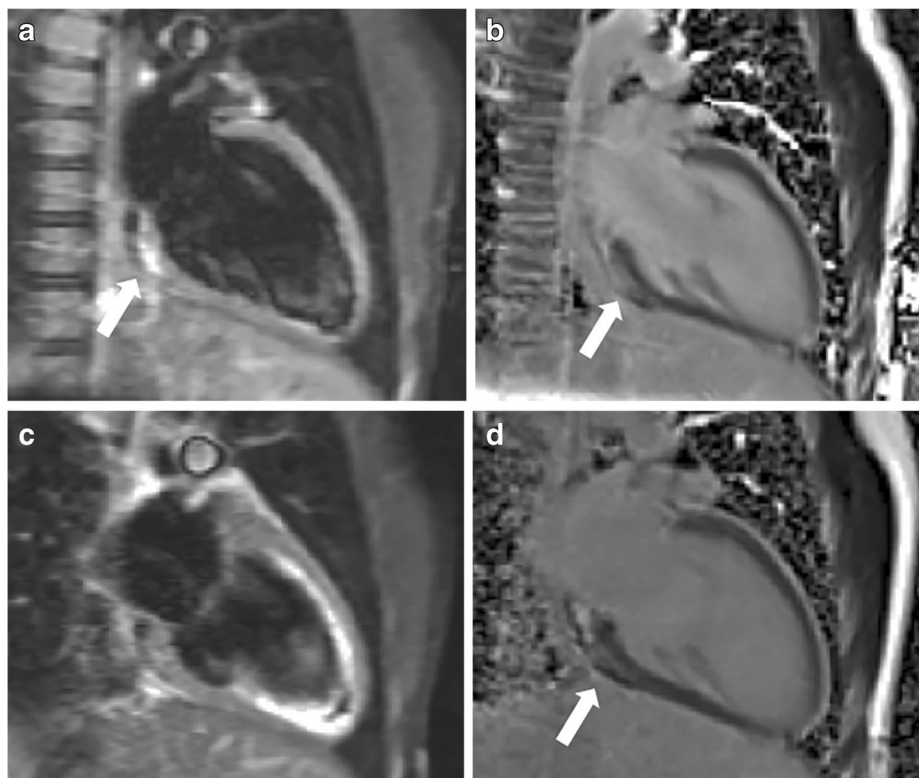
Cardiovascular MRI in a 13-year-old boy, patient 3. a, b Presentation. Vertical long-axis short tau inversion recovery (STIR) image (a) shows myocardial oedema/inflammation (*arrow*) and subepicardial enhancement. Late gadolinium enhancement vertical long-axis image (b) shows the basal inferior wall at the time of presentation (*arrow*). c, d Follow-up at 2 months. Repeat cardiovascular MRI (*black circle* outlines the left pulmonary artery) shows no myocardial oedema/acute inflammation (c, vertical long-axis view, STIR image). A small region of residual subepicardial fibrosis is limited to the basal inferior wall (d, vertical long-axis view, late gadolinium enhancement image, *arrow*)
